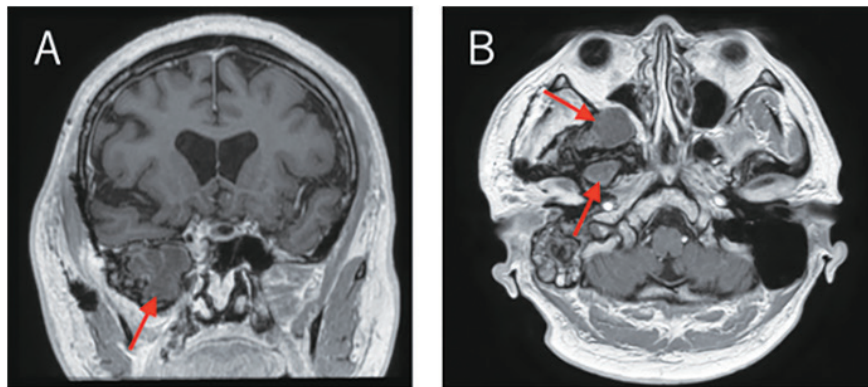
A, B; MRI (A; coronal view/B; axial view) with contrast enhancement after the first surgery. There is a residual tumor of the ABCs in the deep temporal fossa to the pterygopalatine fossa (arrow).
